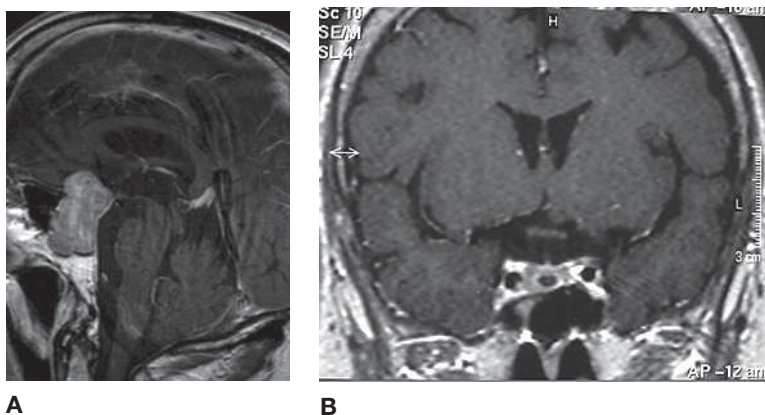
Pituitary adenomas. (A) Macroadenoma. Sagittal post-contrast MRI shows a large, heterogeneously enhancing mass in the midline expanding the sella and extending into the anterior cranial fossa of a 42-year-old woman with loss of peripheral vision. (B) Microadenoma. Brain MRI shows mass measuring 8 × 6 mm. (Image A reproduced with permission from USMLE-Rx.com; image B reproduced from Talaei A et al. *J Med Case Rep.* 2014;8:38.)
